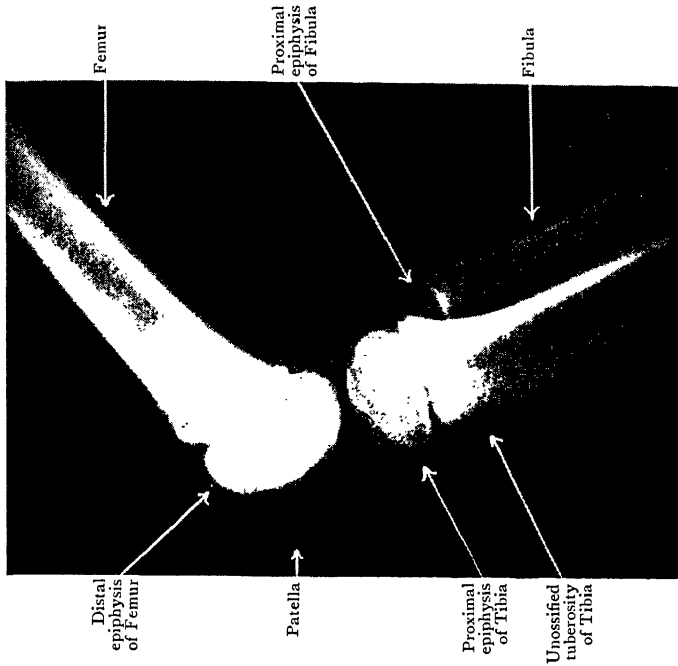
Lateral Radiograph of the same Knee in semi-flexed position. Note that centre for tuberosity of tibia has not appeared and compare with Fig. 180B.
